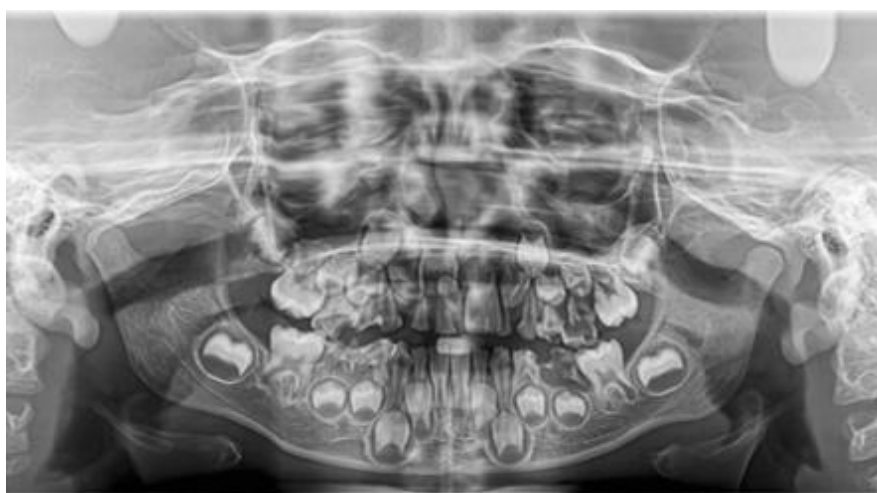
Initial panoramic radiograph, October 2022, showing the impacted, inverted mesiodens in relation to the unerupted tooth 1.1 and the root remnants of teeth 5.1 and 5.2.
